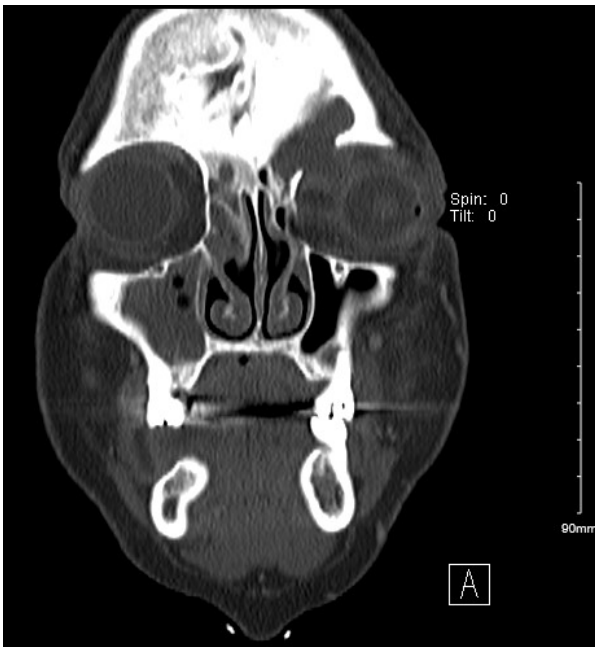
Computed tomography scan of the maxillofacial demonstrating frontal sinus mucocele with contiguous extension through bone erosion through the wall of the anteromedial left orbit.
